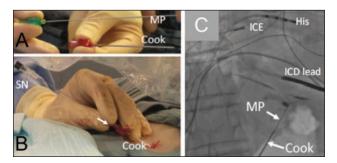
Steps for initial access of the pericardial space using the needle-in-needle technique. Panel A: 21-gauge micropuncture (MP) needle, 18-gauge Cook needle. Panel B: Micropuncture spinal needle (SN) inserted through Cook needle. Panel C: Micropuncture spinal needle (SN) inserted through Cook needle approaching cardiac silhouette. Abbreviations: ICD, implantable cardioverter-defibrillator; ICE, intracardiac echocardiography.
